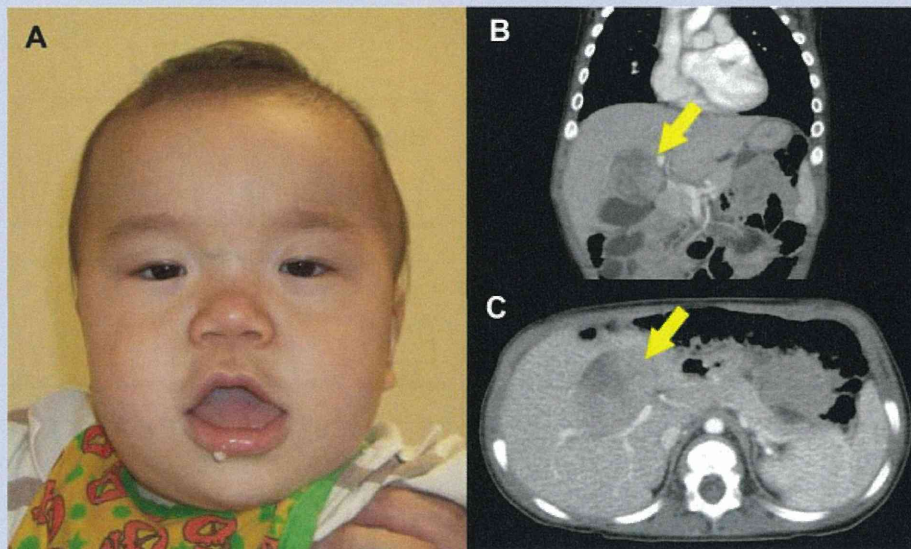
The characteristic facial features and hepatoblastoma in the propositus. A: Note that the facial features of the propositus included upturned bulbous nose, a wide nasal bridge, apparent hypertelorism, macrostomia, macroglossia, and a midline grooved tongue. B and C: Coronal (B) and axial (C) slices of magnetic resonance imaging at 9 months of age showed a well-demarcated heterogeneously enhancing mass, measuring 45 mm × 35 mm × 35 mm, in S4 of the liver (yellow arrows).
